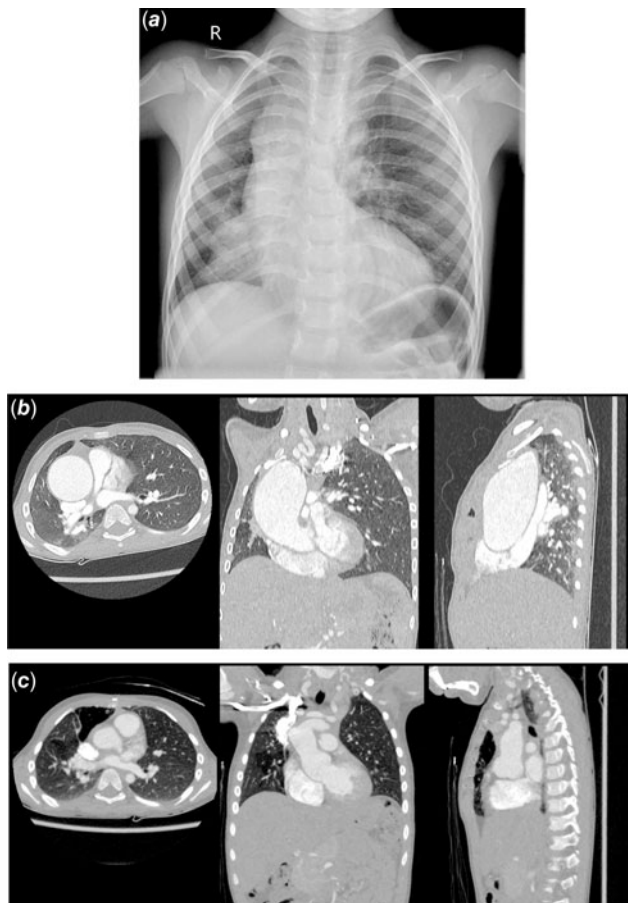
[a] Posteroanterior chest radiograph acquired at the time of initial presentation; [b] (from left to right) axial, coronal, and sagittal preoperative images of CT angiography (CTA), exhibiting the aneurysm. Axial image is at the level of Th7 vertebra; [c] (from left to right) axial, coronal, and sagittal postoperative CTA images acquired one year after the procedure. Axial image is at the level of Th7 vertebra.
